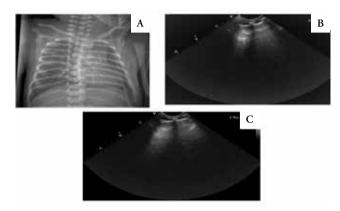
The Chest X-Ray (A) and Lung Ultrasound (B, Right Lung and C, Left Lung) of Neonate 1
